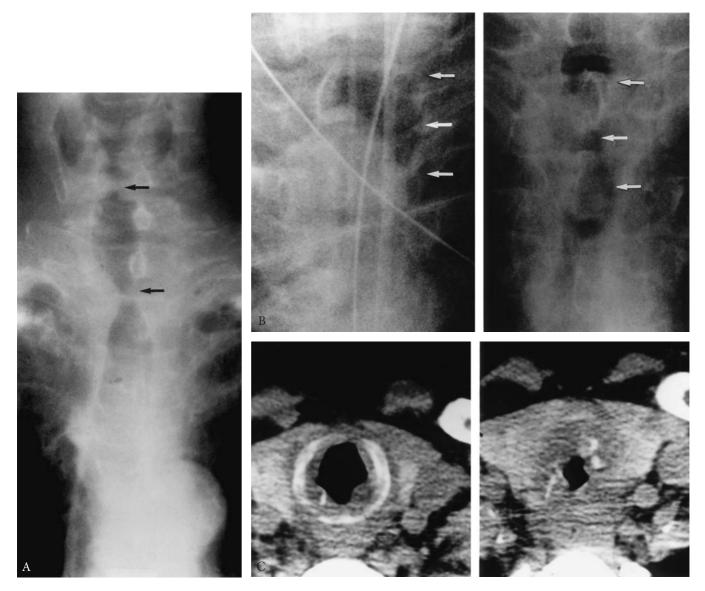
Roentgenographic delineation of postintubation stenosis. A, Filtered view of entire upper airway, in a 60-year-old man with recurrent upper tracheal stenosis after prior resection of the stomal stenosis elsewhere. Stenosis followed ventilation via tracheostomy for respiratory failure after coronary artery surgery. Easily identifiable are the false vocal cords, glottis (arrow), subglottic larynx, stenosis (arrow), and the length of normal trachea remaining. B, Evolution of a cuff stenosis for ventilation with an endotracheal tube only. On the left is a detail from a chest x-ray showing the endotracheal tube and the distended balloon cuff (arrows). On the right is the stenosis (arrows) in the same tracheal segment, from another plain chest x-ray. C, The stenotic lesion from B shown on a computed tomography scan. The left image shows the beginning of the stenosis whereas the right image shows the middle of the lesion. Note the nearly complete destruction of the cartilage, and the massive scar tissue contracting the lumen to a fraction of normal cross section.
